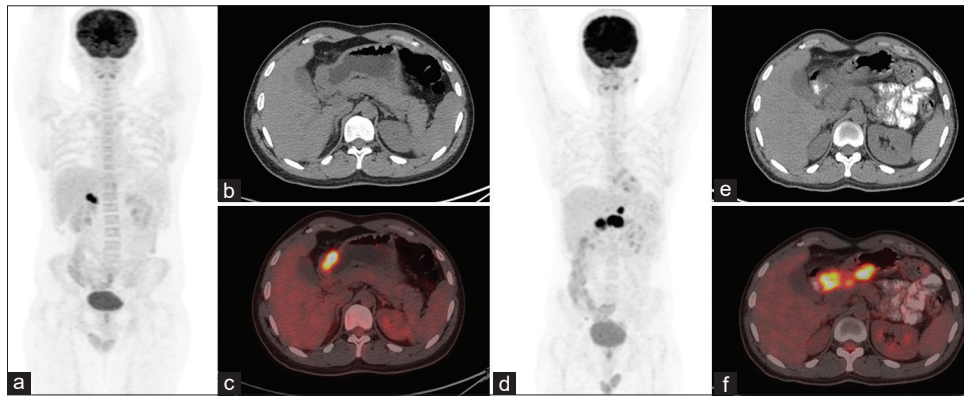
Case of 22-year-old male who was diagnosed with gastric lymphoma (B-NHL) and was advised Baseline Positron emission tomography/computed tomography (MIP [a], Axial computed tomography [b], Axial Positron emission tomography/computed tomography [c]); which revealed a metabolically active thickening involving the distal stomach and no other site of involvement; thereby confirming the diagnosis of primary gastric lymphoma and ruling out gastric involvement by systemic lymphomatous disease. He was started on chemotherapy and underwent Positron emission tomography/computed tomography after 3 months (MIP [d], Axial computed tomography [e], Axial Positron emission tomography/computed tomography [f]); which revealed increase in the extent of the earlier lesion as well as appearance of a new perigastric lymph nodal lesion– indicative of progressive disease
